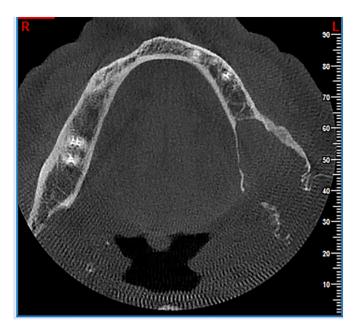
Axial CT scan of mandible shows a large lytic expansile mass lesion in left mandibular body with cortical destruction.
